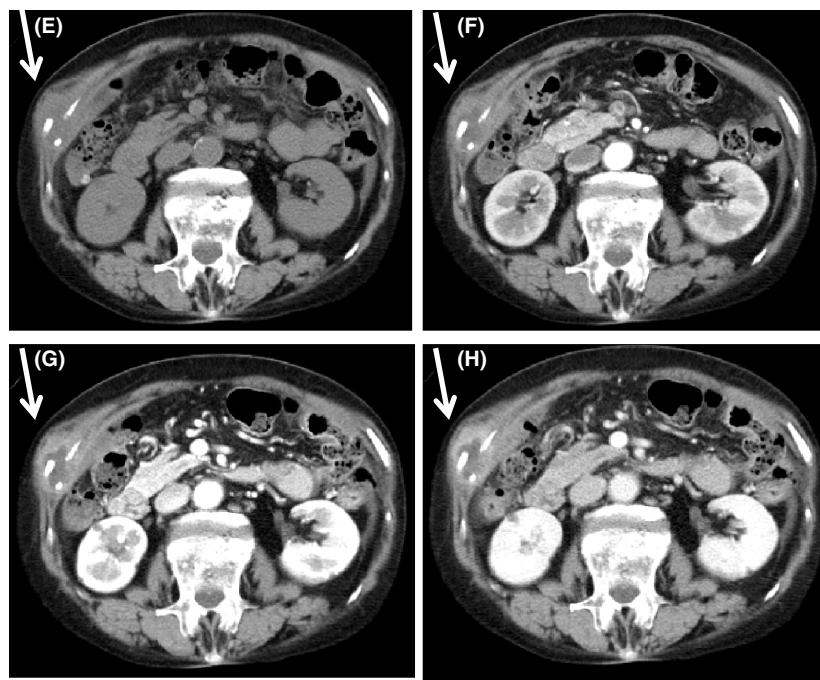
(A–D) Abdominal ultrasound findings at 78 days after first admission. (B–D) A 4-cm tumor is seen at the right rib. (A) Abdominal ultrasound shows a moderate amount of ascites. (B, C) Ultrasound finding of tumor in the 10th right rib is heterogeneous. (D) Doppler ultrasound finding of tumor in the 10th right rib is hypovascular. (E–H) Abdominal unenhanced and enhanced computed tomography (CT) scan findings at 78 days after first admission. (E) Plane, (F) arterial phase, (G) equilibrium phase, and (H) venous phase. Tumor in the 10th right rib is showed by an arrow. In addition, the surroundings of the tumor are enhanced in the venous phase.
